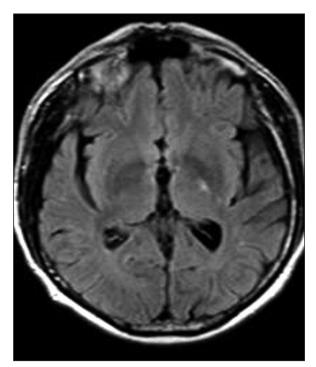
Axial FLAIR (fluid attenuated inversion recovery) shows no infarctions elsewhere.
